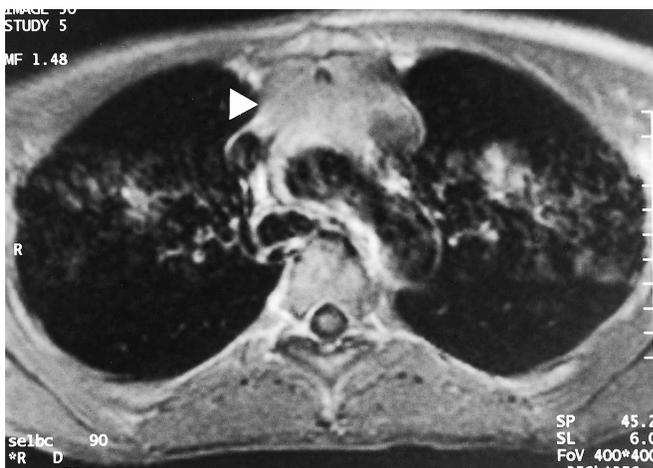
Thymoma. T2-weighted axial MRI of the mediastinum, after intravenous gadolinium-DTPA contrast, at the level of the aortic arch shows a large enhancing tumor (arrow)
